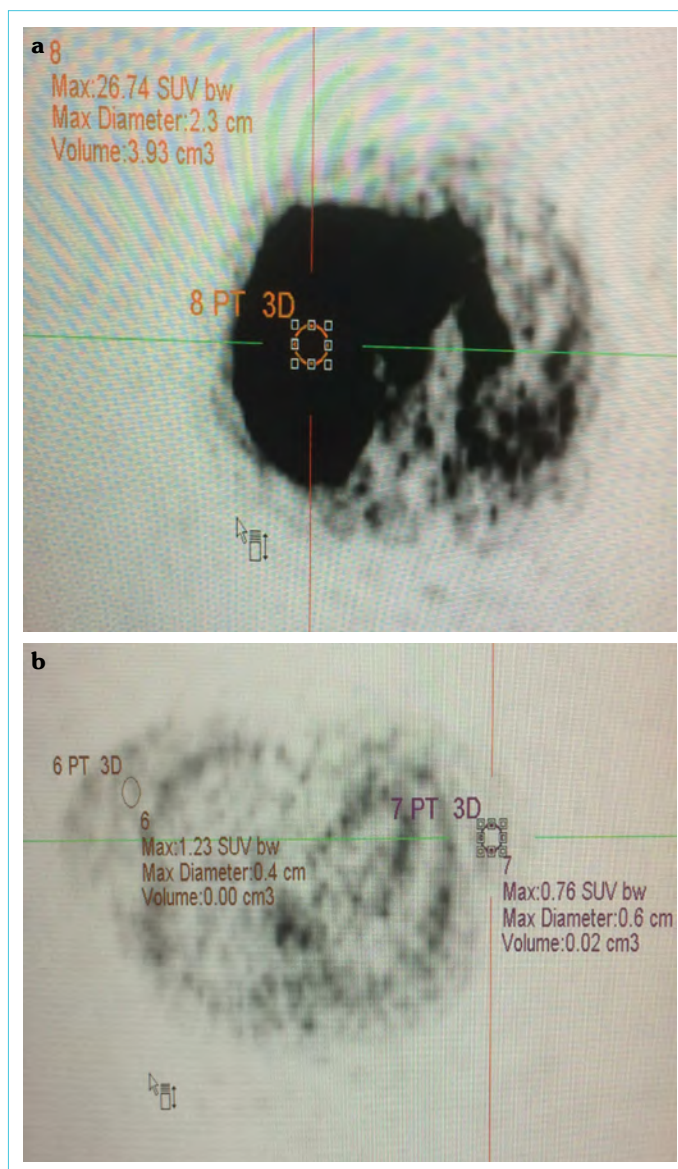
(a) Image of 18F-FCH at 5 minutes in liver with SUVmax: 26.74 g/dl. (b) Image of 18F-FCH at 5 minutes in lesion breast with SUVmax 1.23 g/dl and normal tissue breast with SUVmax: 0.76 g/dl
